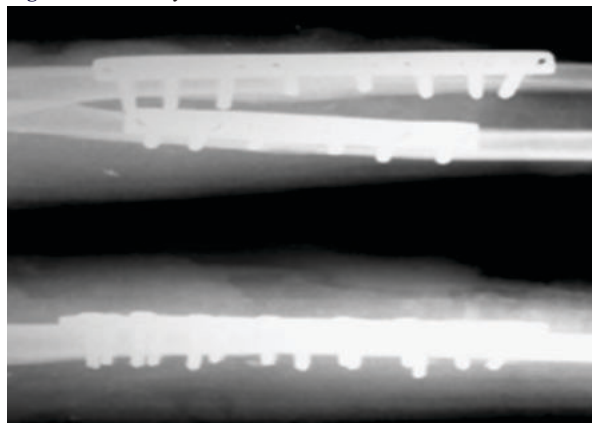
Post-OP(6 months) X-Ray of forearm
